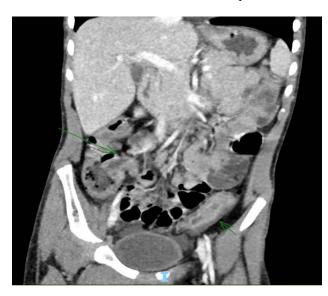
A selected coronal image from the contrastenhanced abdominal CT demonstrates pancolitis, which is most pronounced in the rectosigmoid colon (short green arrow), along with associated terminal ileitis (long green arrow).
